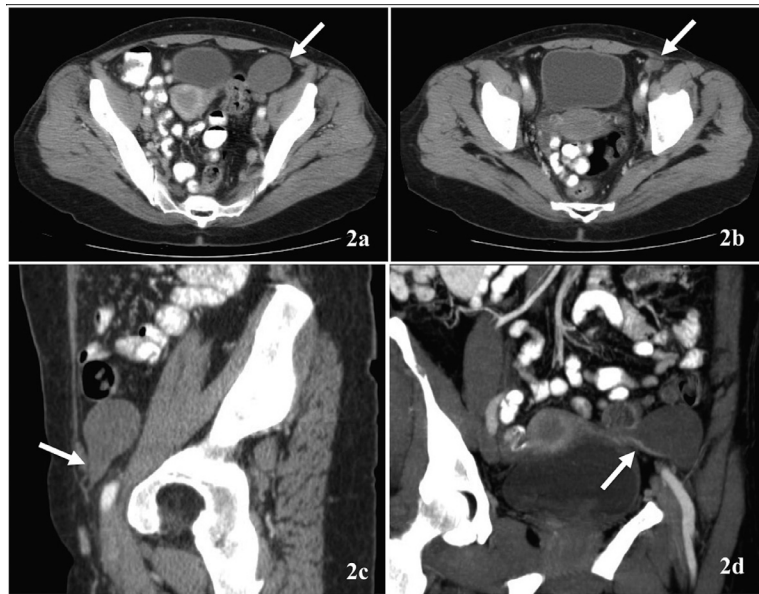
CT of the abdomen and pelvis, with intravenous and oral contrast, and in a portal-venous phase. (a) and (b) are transaxial images at the level of the pelvis (in soft tissue windows), and show an oval well-defined, uniform, soft tissue density, enhancing mass (white arrow). (c) is an oblique maximum intensity projection image showing the extension of the mass into the left inguinal canal (white arrow). (d) is an oblique maximum intensity projection image showing a round ligament vessel supplying the mass (white arrow)
